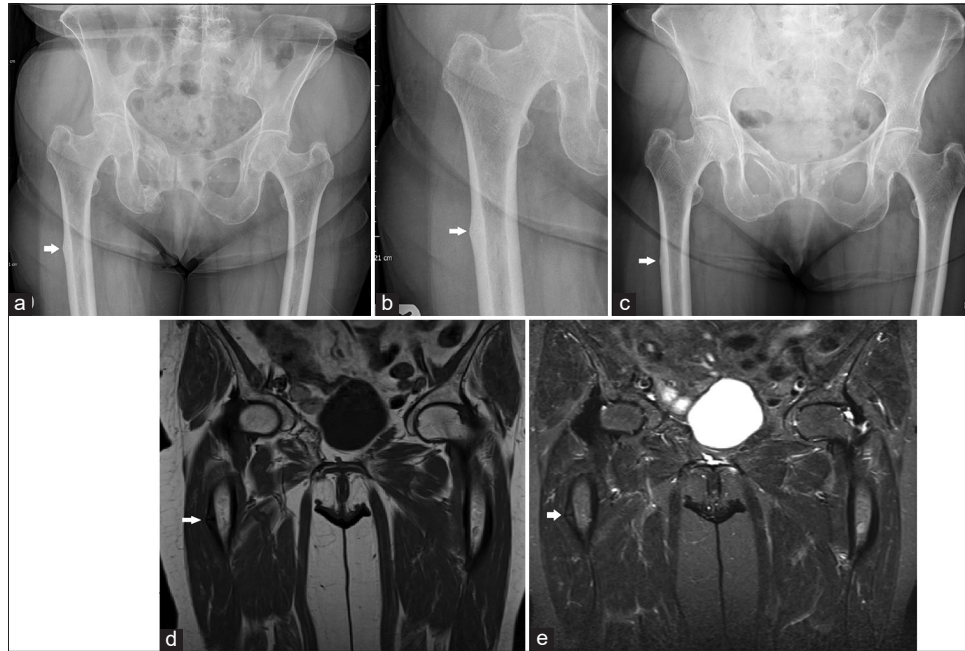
(a) An 82-year-old female presented with post-traumatic right hip pain. The pelvic radiograph demonstrated lateral cortical beaking in the proximal right femur (solid white arrow). (b) Magnified image of Figure 2a, the lateral cortical beaking can be seen (solid white arrow). (c) A pelvic radiograph acquired 4 years earlier, demonstrated subtle lateral cortical beaking in the proximal right femur (solid white arrow). (d) MR coronal T1W sequence demonstrated cortical thickening along the proximal right femur (solid white arrow). (e) MR coronal STIR sequence demonstrated the cortical beaking is solid white arrow with no evidence of bone marrow edema in the proximal right femur. MR: Magnetic resonance, STIR: Short-tau inversion signal.
